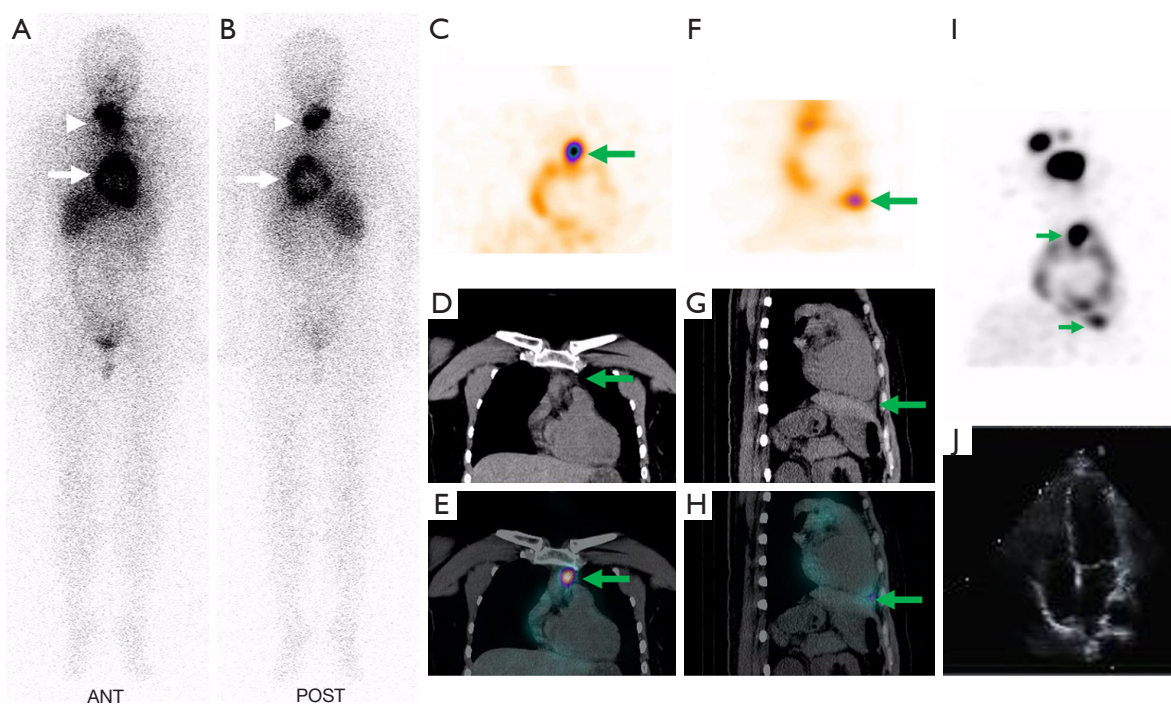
Posttherapeutic ^{131}I WBS and SPECT/CT findings. ^{131}I WBS showed two foci of ^{131}I (A,B, arrow and arrowhead; A: anterior view; B: posterior view). SPECT/CT was performed and revealed minimal pericardial effusion in the superior pericardial recess (C-E, arrows; SPECT: C; CT: D; SPECT/CT fusion: E) and the anterior inferior sinus of the pericardium (F-H, arrows; SPECT: F; CT: G; SPECT/CT fusion: H). In the maximum intensity projection image (I), heart-like pattern foci were observed in the pericardium, especially in the superior pericardial recess and anterior inferior sinus of the pericardium. After 5 days of levothyroxine therapy, the patient underwent echocardiography, which had normal findings (J). WBS, whole-body scan; SPECT, single-photon emission computed tomography; CT, computed tomography; ^{131}I , iodine-131.
